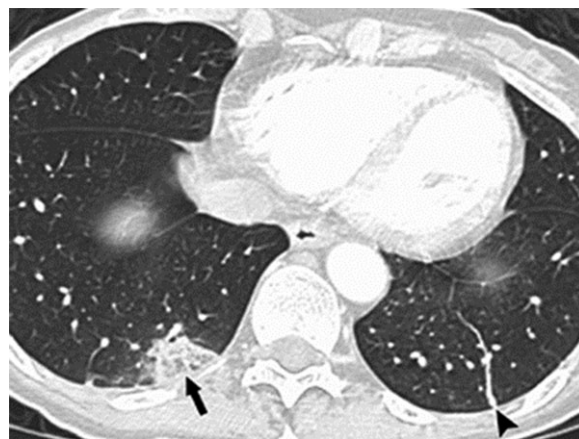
Acute pulmonary embolism in a 58-year-old woman who presented with chest pain and dyspnea. CT scan shows an acute pulmonary embolus with ancillary findings of a peripheral wedge-shaped area of hyper attenuation in the lung (arrow), a finding that may represent an infarct, as well as a linear band (arrowhead)
